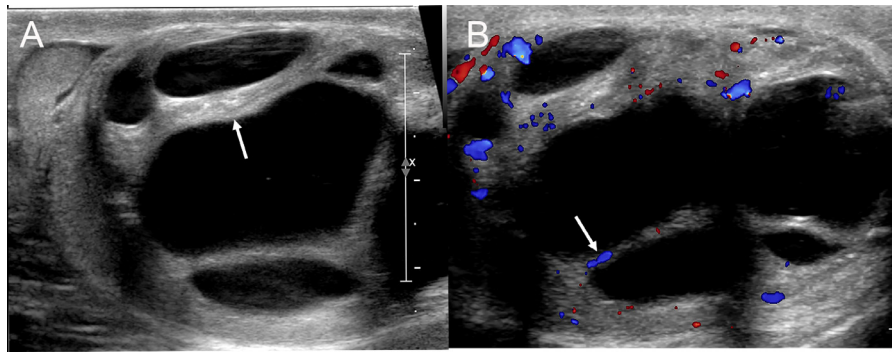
Primary borderline mucinous tumor of the testis: Ultrasound examination showed a cystic mass with clear boundaries and internal irregular septations of varying thickness (A, the arrow) and linear blood flow signals above the septum (B, the arrow) in Color Doppler flow imaging.
